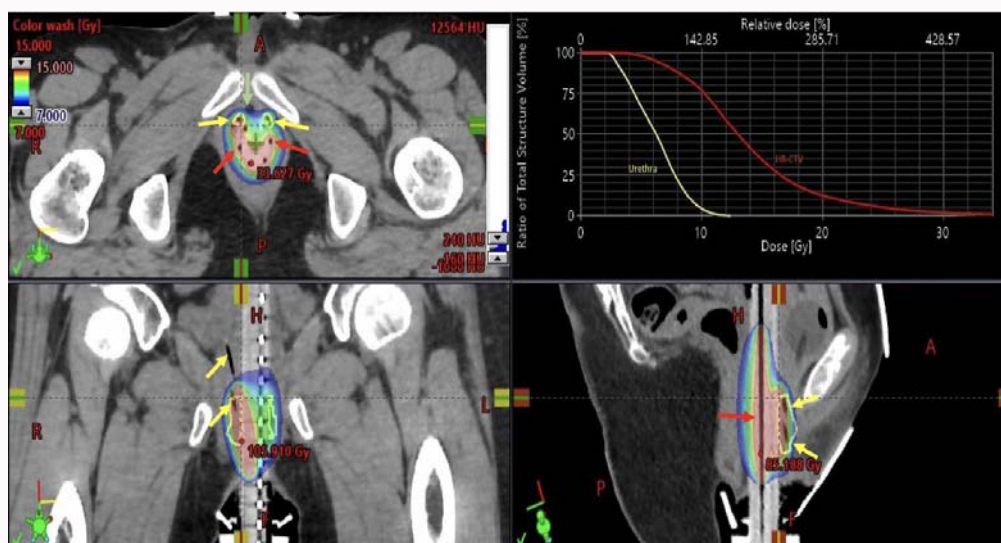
MRI based Image Adapted HDR Brachytherapy delivering target dose using multichannel applicator (red arrows) and interstitial needles (yellow arrows). Urethra (green arrow) is relatively spare.
